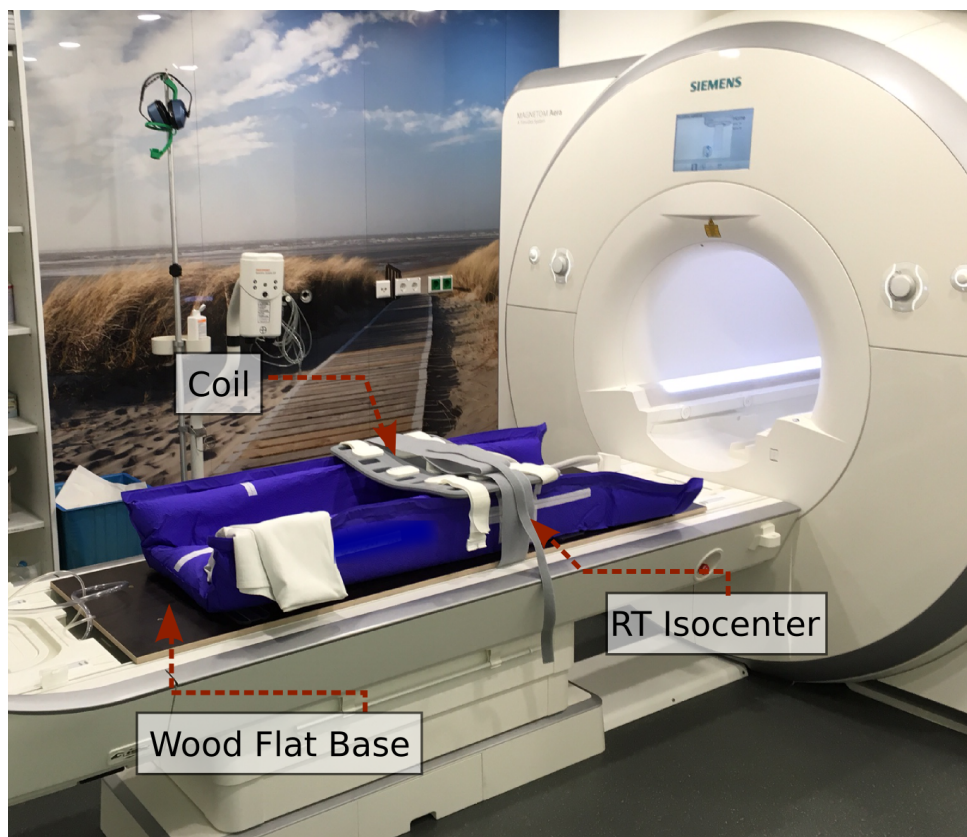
Setup of the MRI acquisition for the pancreatic patients treated at HIT and imaged in the National Center for Tumour Diseases (NCT). The apparatus consists of the patient specific vacuum mattress indexed to a wood flat base that is attached to the MRI's couch. The body coil is then placed in the patient's RT isocentre.
